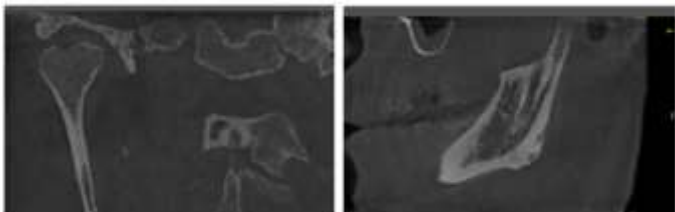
CBCT scan of Right & Left TMJ showing irregularity along superior surface of condylar head and loss of cortication in the central position.
